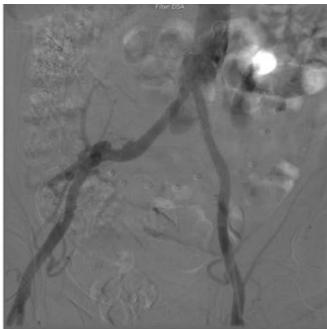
Arteriography demonstrating impact of common iliac stent on erectile function. (A) Iliac angiogram of patient presenting to our clinic with worsened erectile dysfunction (ED) and marked decrease in IIEF-5 scores over previous 2 months. Previously placed left common iliac stent is occluded. (B) Patent stent after ultrasound-accelerated lytic infusion and balloon angioplasty. The patient reported marked improvement in ED with return to baseline IIEF-5 scores at 2-week follow-up exam.
